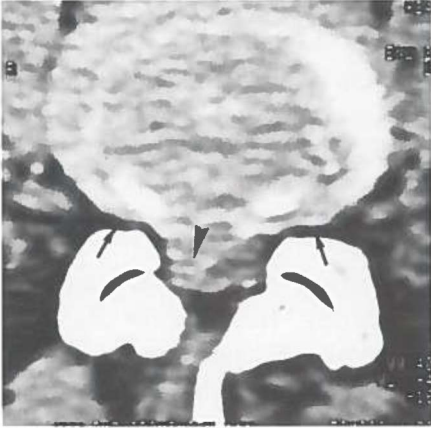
Case 1. CT scan of a right sided posterolateral hernia of disc L4-L5 (arrowhead). Note the symmetrical fat in the neural foramina (small arrows).
